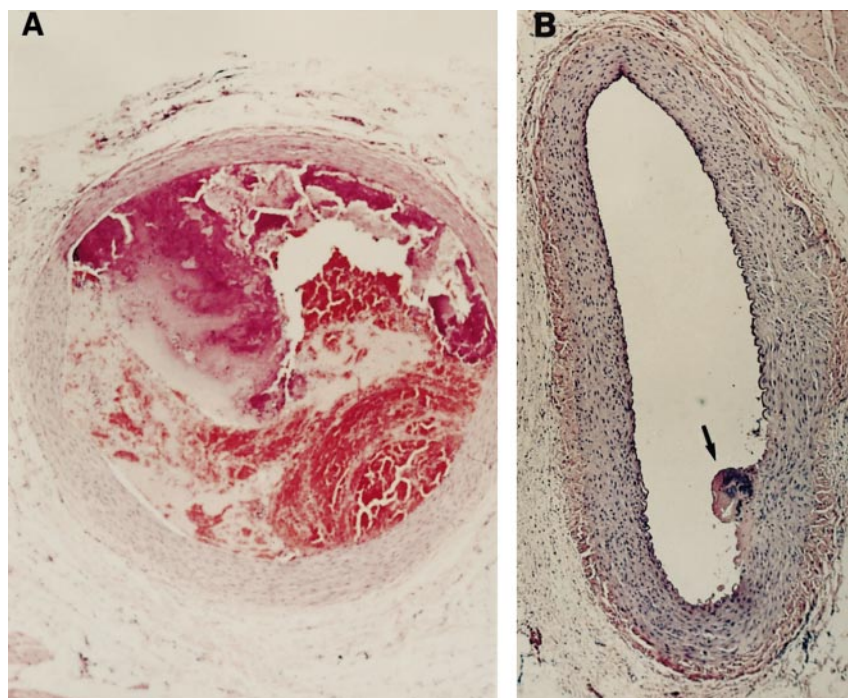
A, Example of persistent LAD occlusion after treatment with t-PA alone; B, patent LAD after treatment with t-PA and ultrasound. Arrow indicates site of intimal damage from electric thrombus induction.
